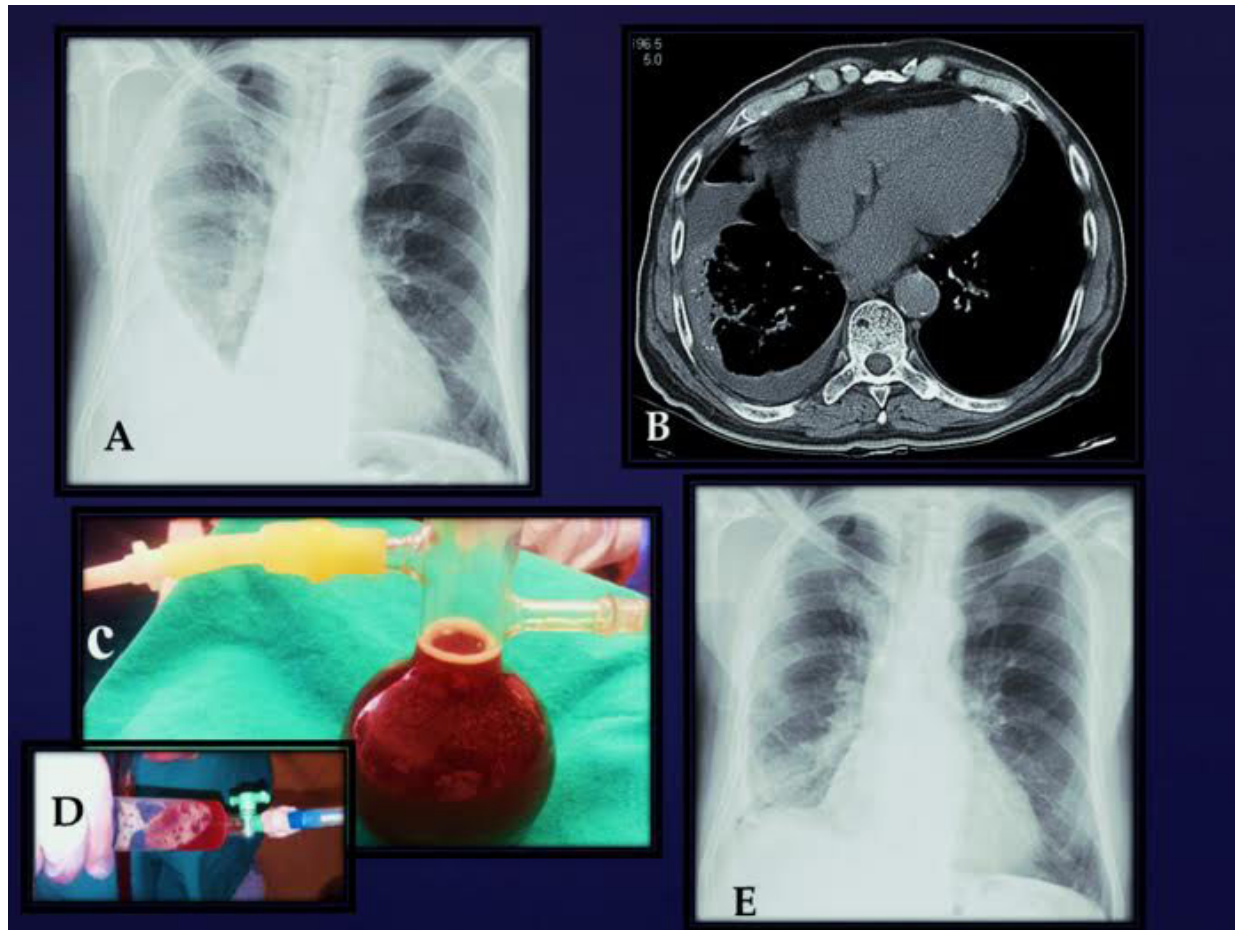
(A) Chest X-ray with right-sided pleural fluid. (B) Thorax computed tomogram showed pleural fluid and bronchiectasis on the right lower lobe. (C,D) Haemorrhagic pleural fluid seen during aspiration. (E) Chest X-ray after drainage of the fluid.
